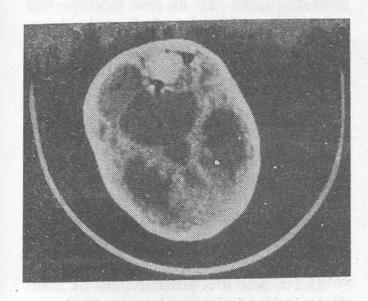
CT head on admission showing hyperdense area in right frontal region (black dots) with moderate hydrocephalus.
